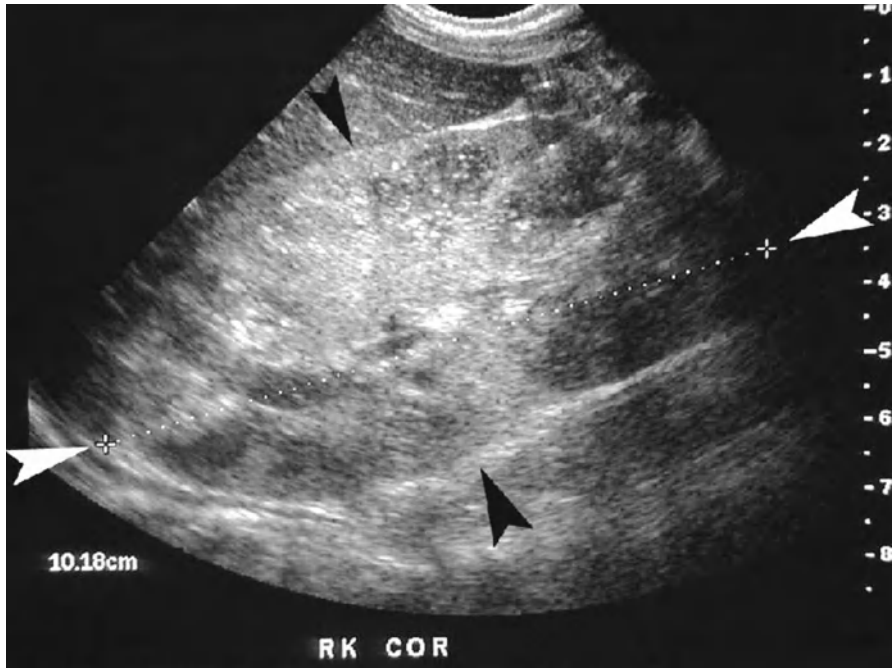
ARPKD on renal ultrasound
